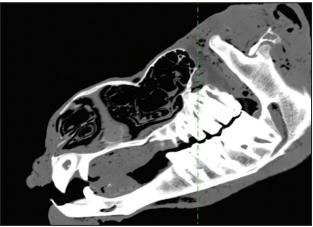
CT image of sagittal plane showing gradually increased width of horizontal ramus caudally merged into vertical ramus.
